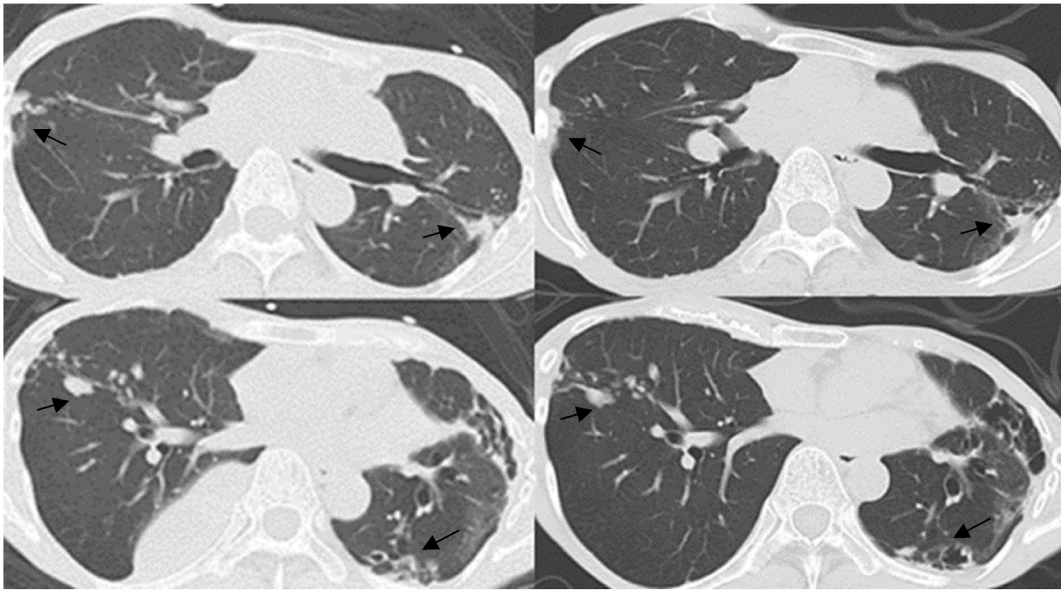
CT images of the left side showed right hemopneumothorax on day 406. Images of the right side were taken at the end of MAC treatments. Both show improvements of granular shadows and consolidations (black arrows) in the bilateral lungs.
